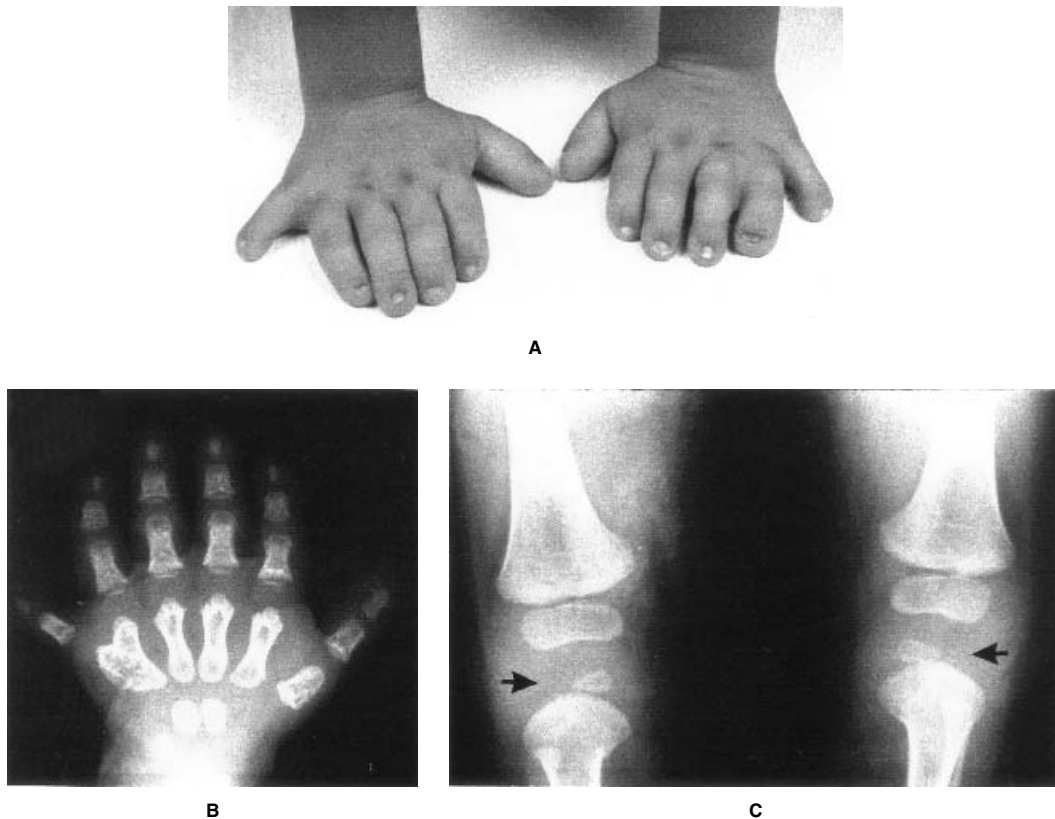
Ellis-van Creveld syndrome. (A) Hands of a 2-year-old girl with Ellis-van Creveld syndrome showing broad fingers, hypoplastic nails and postaxial polydactyly. (B) Radiograph of individual in (A) showing postaxial polydactyly with bony fusion of extra metacarpal and metacarpal V, short and broad middle phalanges with partial duplication of middle and terminal phalanx of finger IV, cone shaped epiphyses and hypoplastic distal phalanges. (C) Hypoplasia of lateral part of tibial epiphysis (arrows) is a frequent finding in Ellis-van Creveld syndrome.
